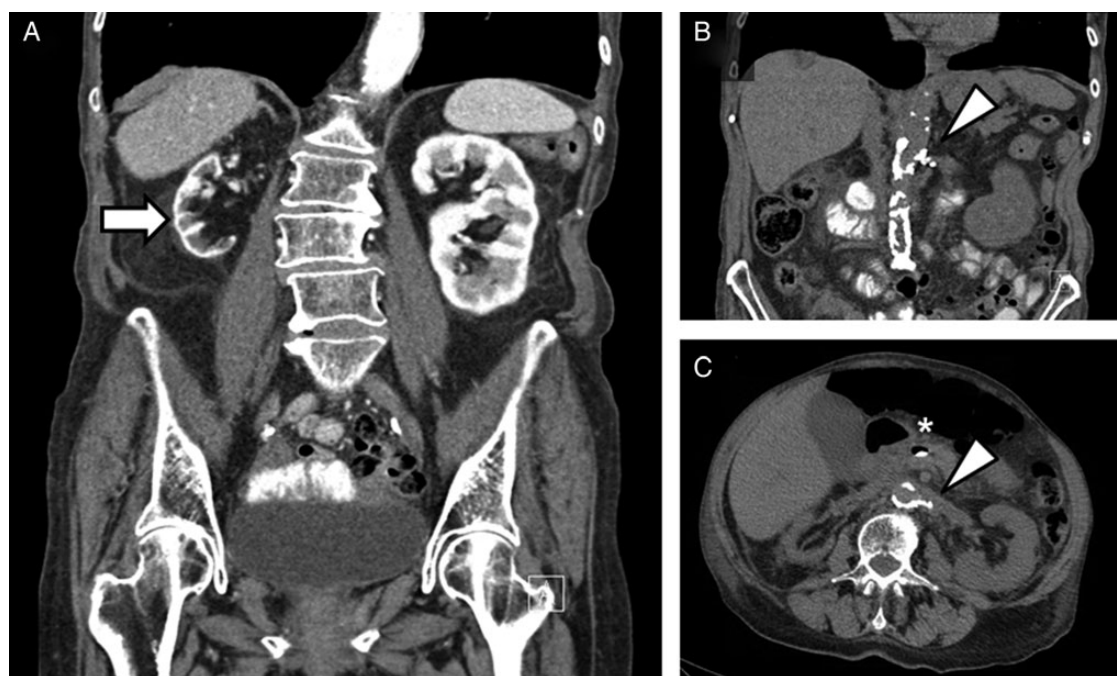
CT-scan findings. (A) Severe atrophy of the right kidney (arrow) incidentally found on the CT scan (coronal sections; with iodine contrast media) performed 3 months before current admission. (B and C) Extensive calcifications of the aorta and the ostium of the left renal artery (arrowhead) on the CT scan performed after ESWL (transversal sections). The pancreatic prosthesis (asterisk) is located in front of the ostium of the left renal artery.
